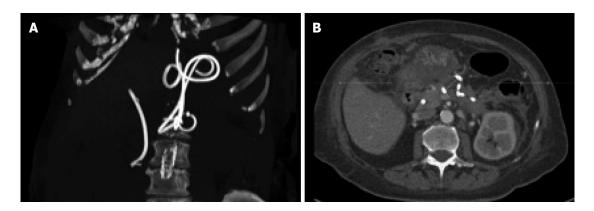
Computed tomography scan performed three weeks later: Scan reconstruction showing the correct position of the biliary and pancreatic collection stents (A), while the axial scan show almost complete resolution of the cystic cavity (B).
